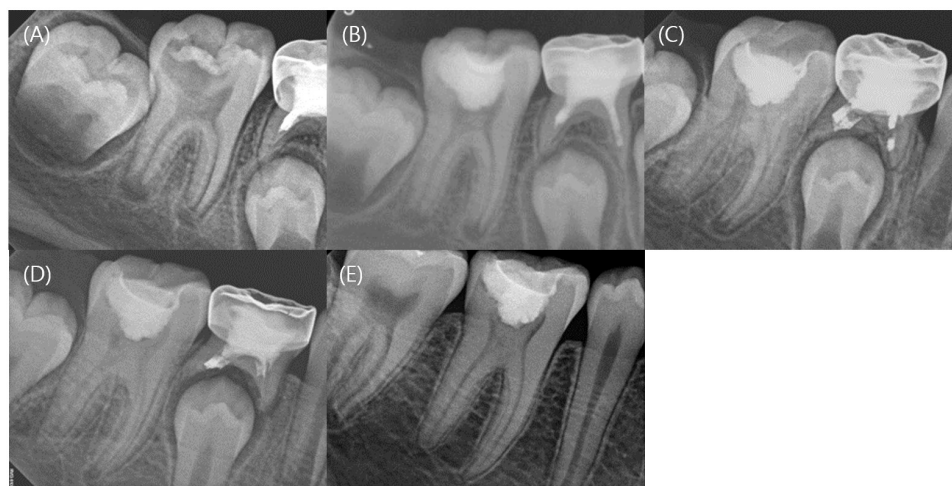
Serial periapical radiographs of Case 2. (A) Pretreatment periapical radiograph of the mandibular right first molar. (B–E) Radiographs at the 3-month, 15-month, 2-year, 5-year follow-ups demonstrating continued root development, apical closure, and progressive canal narrowing.
